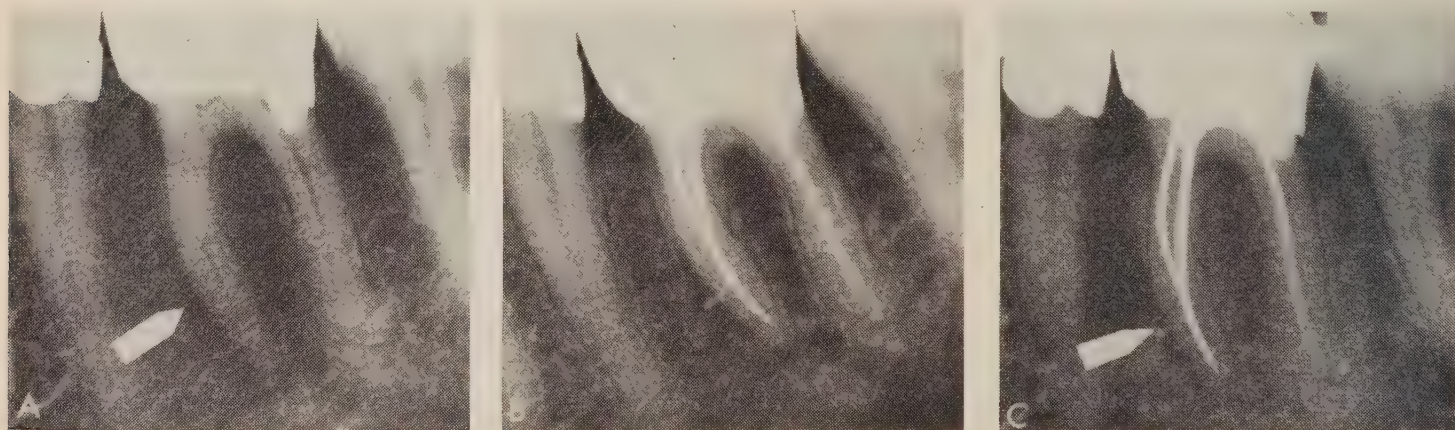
A, pre-operative radiograph of poorly treated maxillary central and lateral incisors. A radiolucency is present on the mesial surface of the central incisor (arrow). B, radiograph taken after the canals were filled. The tapered preparation has retained the filling material and allowed for the extrusion of sealer through the central incisor's auxiliary canal to the radiolucency (arrow). C, radiograph taken one year after treatment. Periapical radiolucencies have disappeared from both teeth.
